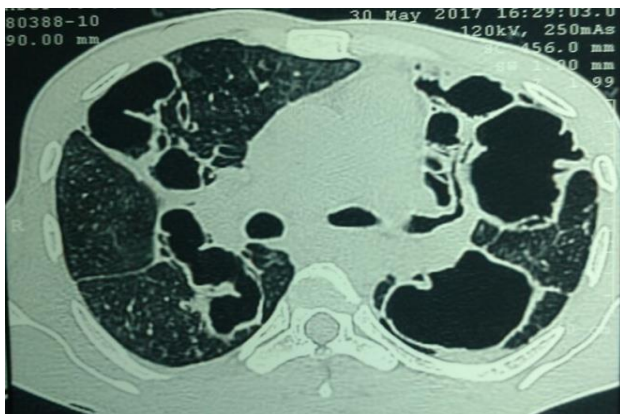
HRCT chest showing bilateral thick walled irregular cavities.
